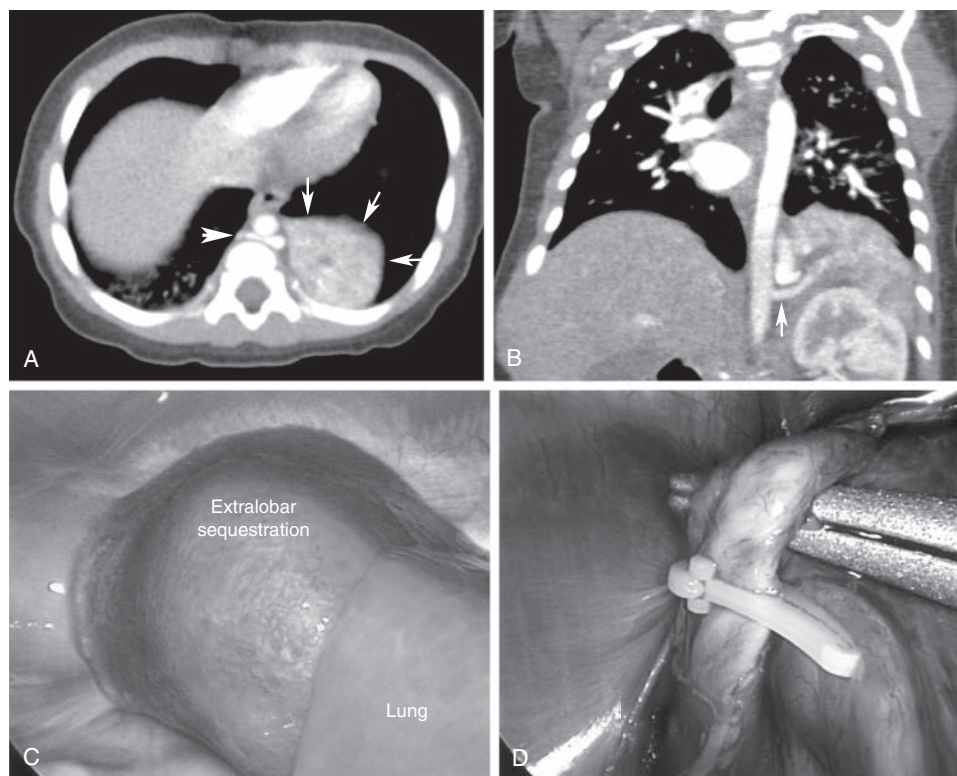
Thoracoscopic resection of a left-sided extralobar pulmonary sequestration (ELPS) in a newborn. A, B, CT scan shows ELPS at base of left chest (arrows in A). Note large vein coursing behind aorta in A (arrowhead) and large artery supplying lesion directly from aorta in B (arrow). C, Thoracoscopic view of ELPS (looking toward diaphragm). D, Clipping of large artery and vein. Lesion is then removed through one of the port sites.
